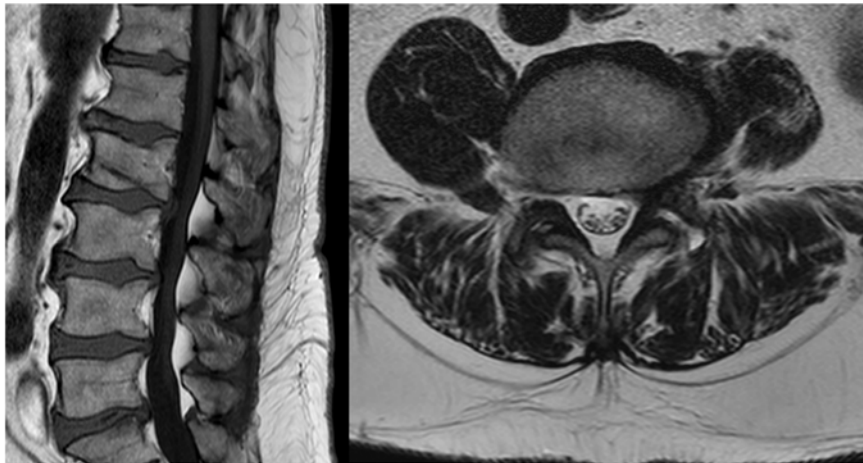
In an MRI study (T1w sagittal image on the left and T2w axial image on the right), performed 5 years before the weight gain, the epidural fat was significantly less voluminous.
